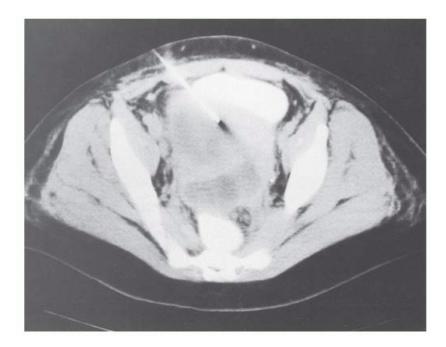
Transabdominal needle aspiration of a pelvic abscess under guidance of CT. Drainage tube is also placed.
